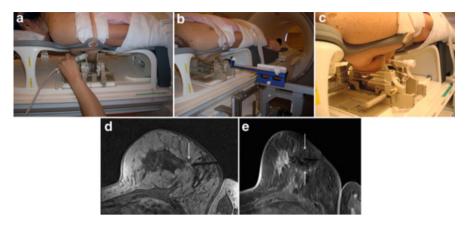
MRI-guided cryoablation (case 1). (a) The breast was moderately compressed using the compression plates. (b) Using the same technique of MRI-guided breast biopsy, the MR-compatible puncture needle was advanced to the appropriate depth. (c) The plastic tube of the puncture needle was left in the breast. (d) Transverse contrast-enhanced T1-weighted MR image shows an enhanced tumor (*arrow*) and the inserted plastic tube. (e) Transverse contrast-enhanced, fat-suppressed T1-weighted MR image shows that tumor is completely encased within the ablation zone (*arrows*)
